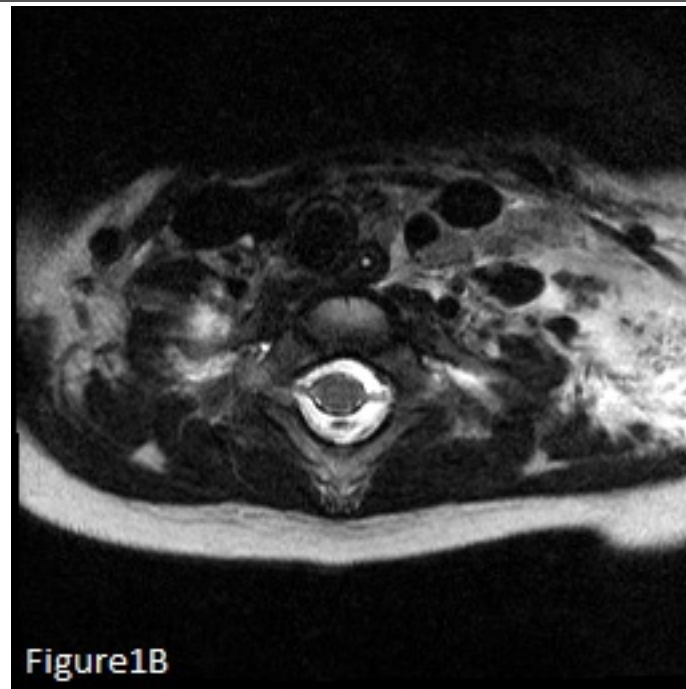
(A) Sagittal and (B) axial T2-weighted MRI Cervical Spine without contrast demonstrating noncompressive epidural hematoma extending from C5 to the upper thoracic spine. Also seen is prevertebral fluid edema extending from the odontoid tip down to C3 with anterior displacement of the anterior longitudinal ligament.
